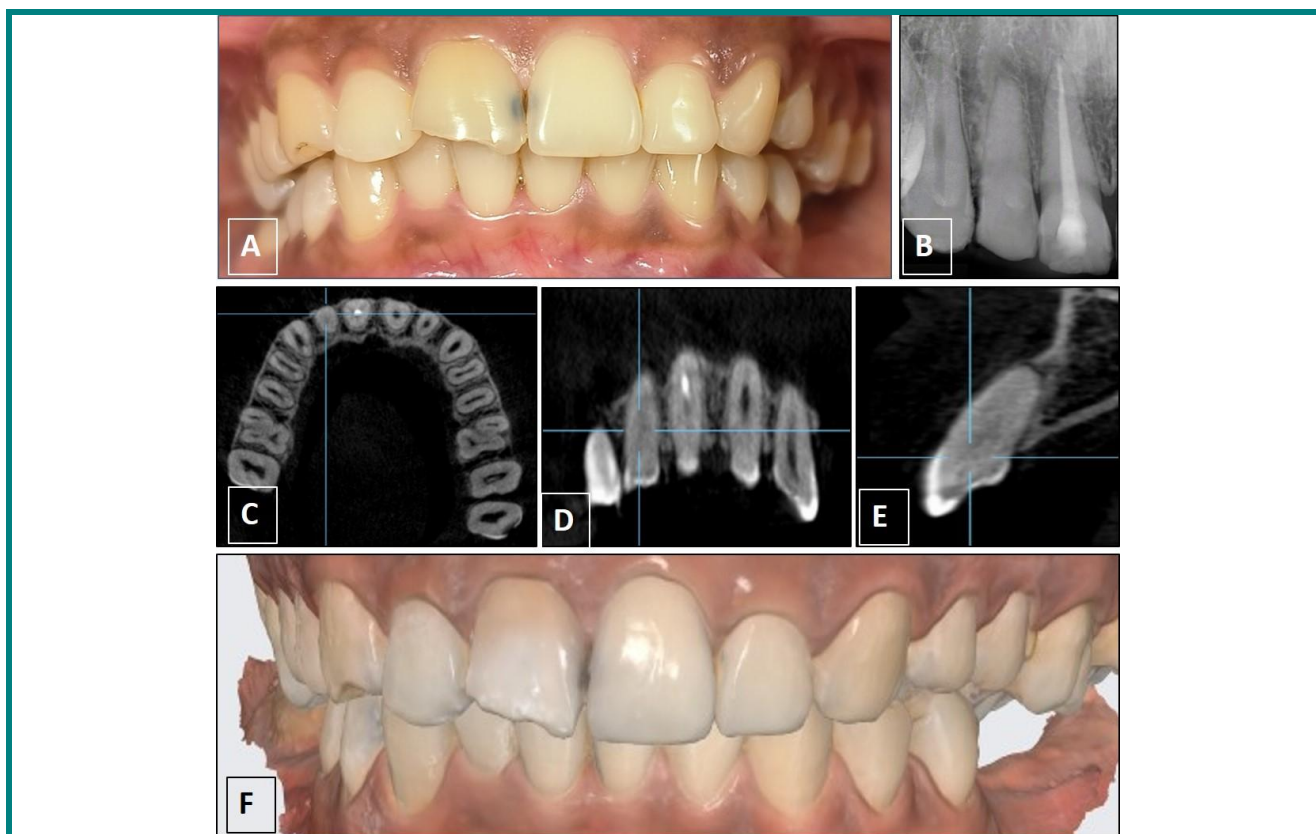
This figure demonstrates clinical, radiographic, cone beam computed tomographic images and stereo-lithographic (STL) data obtained from scanning. A. Clinical photograph, B. Radiographic image, C-E. Axial, coronal and sagittal views, respectively, and F. STL data.
